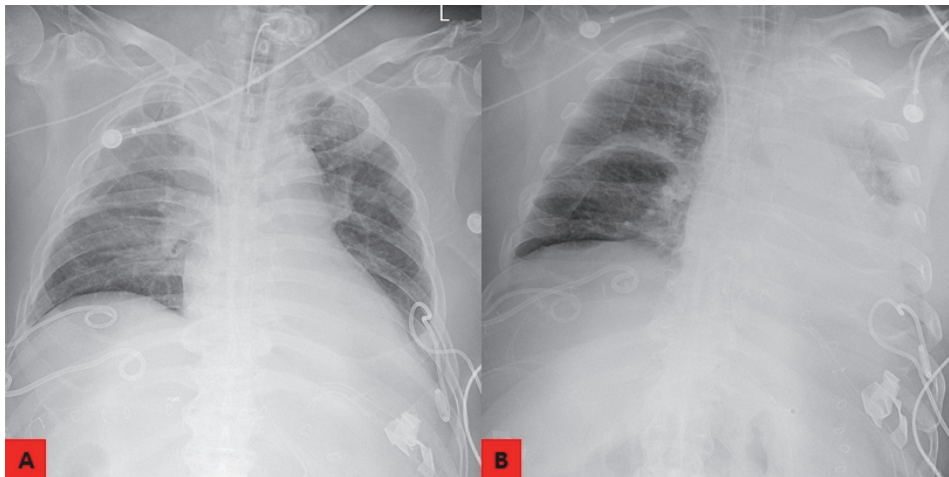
On the 20th day of tracheostomy, no atelectasis was observed in the AP chest radiography. (A) However, total atelectasis in the left lung is observed in the AP chest radiography performed at the following day (B).
